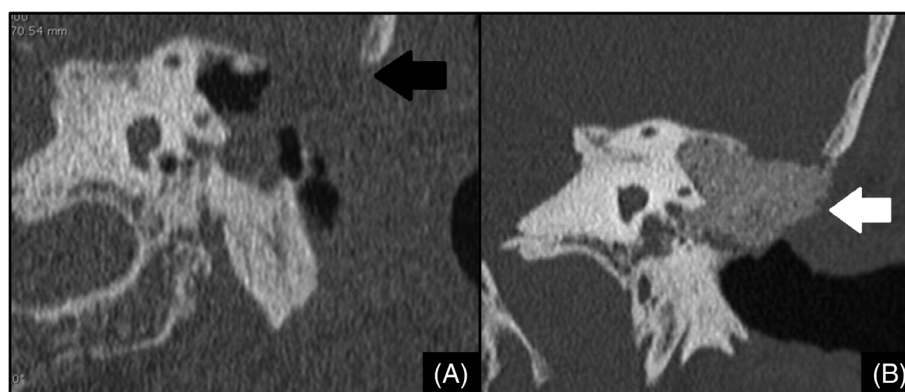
A, Preoperative coronal high-resolution CT (HRCT) image showing a large defect in the mastoid tegmen (black arrow) associated with a meningoencephalocele following multiple surgical procedures for cholesteatoma removal. This patient underwent surgery to repair a tegmen bony defect and rehabilitation of the canal-wall-down mastoidectomy using S53P4 bioactive glass granules. B, Postoperative HRCT image showed the stability of the reconstruction (white arrow) during the follow-up
